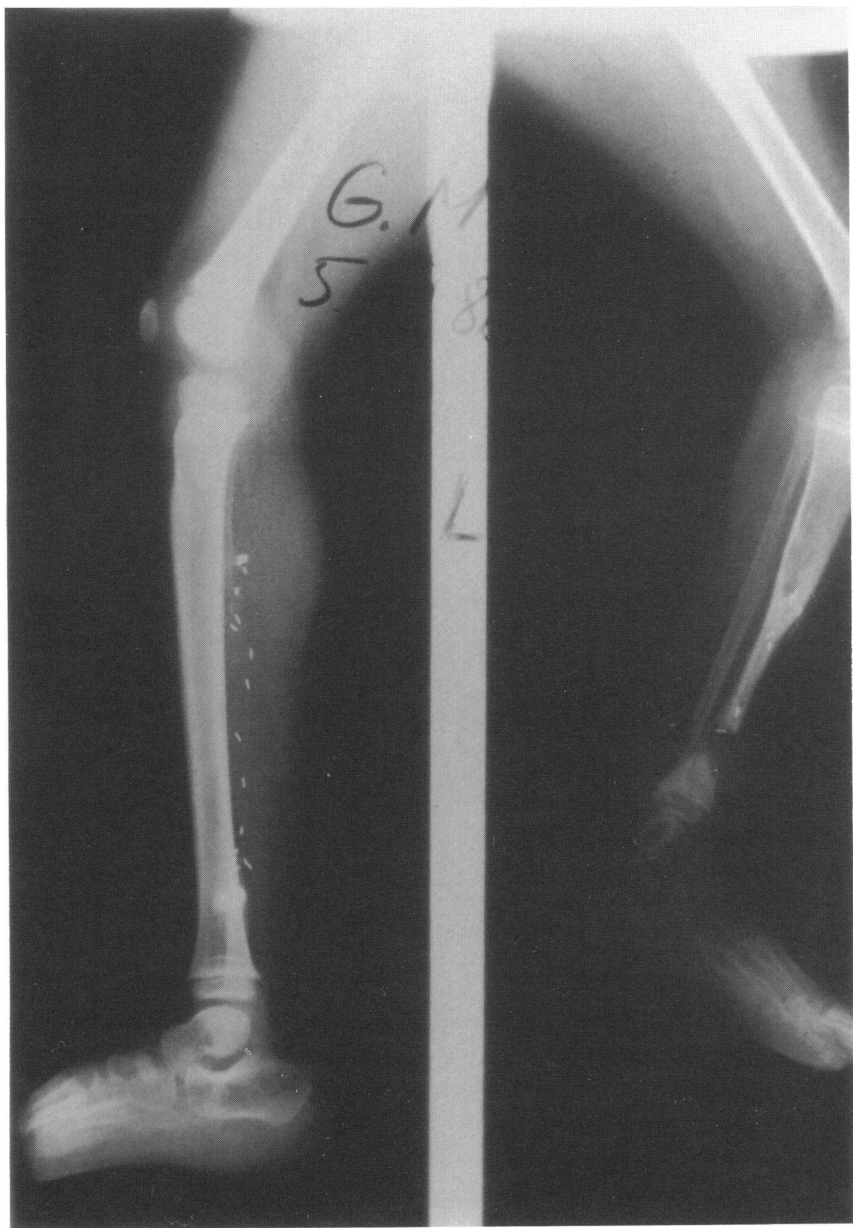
X-ray before treatment
